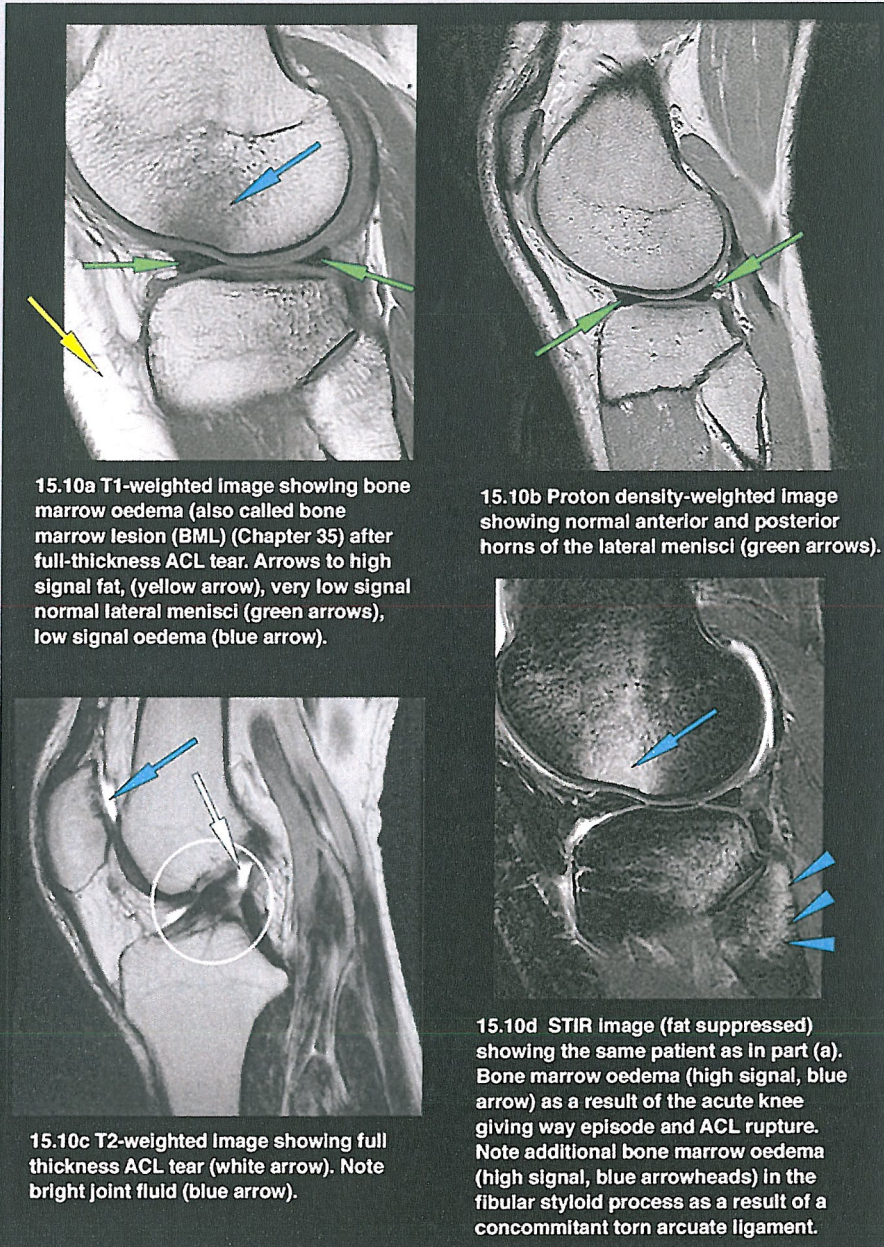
The legend for the arrows/arrowheads to structures in the four MRI sequences is as follows: fat = yellow; tendon and ligament = off-white; water = blue; menisci = green
